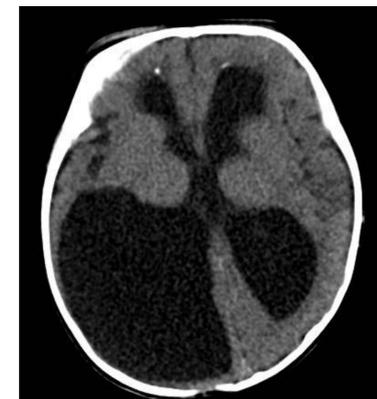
CT scan showing hydrocephalus, right occipital porencephaly, left occipital lobe atrophy, and periventricular calcification
